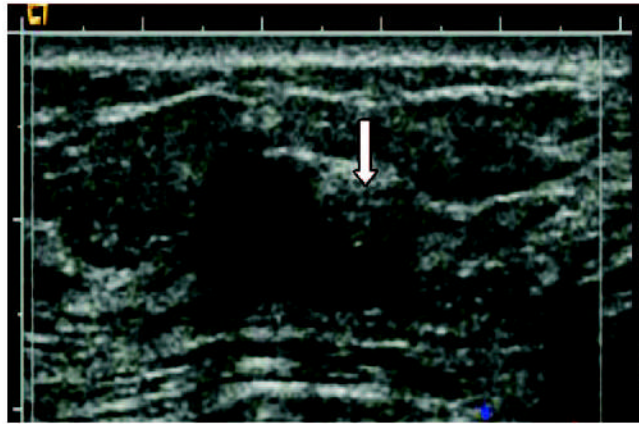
US image and hemoglobin concentration maps of suspicious 6-mm lesion located at 7 o'clock position in right breast of same patient as Figure 5. (a) US image demonstrates lesion (arrow). No blood vessels or blood flow were seen at color Doppler US. Biopsy result revealed benign nonproliferative fibroadipose breast tissue. (b) Total hemoglobin concentration map computed from absorption maps (not shown) obtained at 780 nm and 830 nm. No resolvable lesion was found in hemoglobin map, and maximum total hemoglobin concentration was only 24.2  $\mu\text{mol/L}$ . Vertical scale represents total hemoglobin concentration in micromoles and ranges from 0 to 150  $\mu\text{mol/L}$ .
